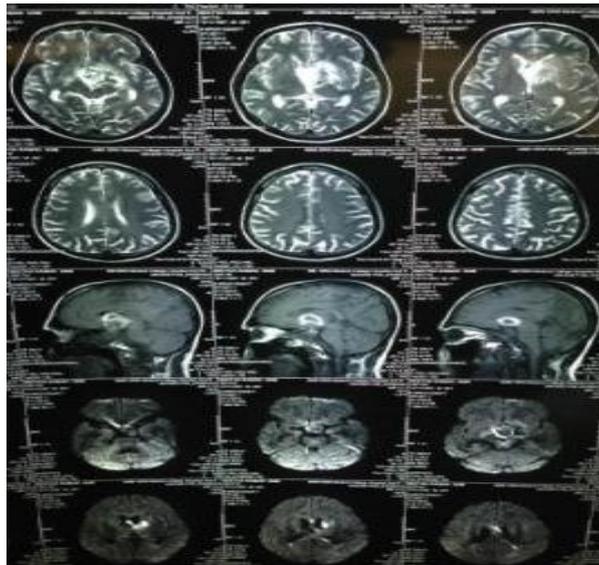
MRI Brain sagittal view with subarachnoid hemorrhage Compression 3rd ventricle and dilatation of lateral and 4th ventricle
